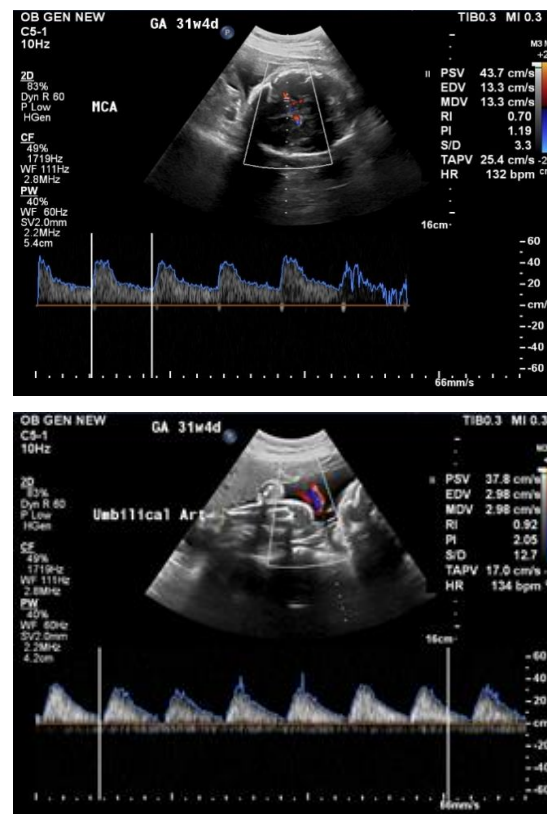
Colour doppler indicating abnormal cerebro placental ratio indicated by MCA PI and umbilical artery PI
